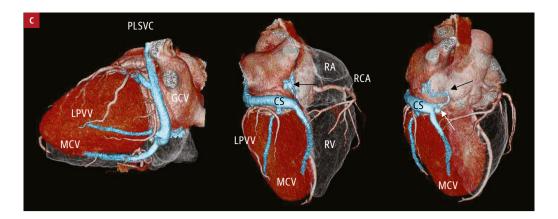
C – 3-dimensional volume-rendered reconstruction images of cardiac computed tomography showing atresia of the coronary sinus (CS) ostium with persistent left superior vena cava (PLSVC) (left, left posterior oblique view; middle, caudal view; right, right oblique caudal view). The right atrium (RA) and right ventricle (RV) are shown in outline for clarity. White arrow indicates an anomalous vein arising from the CS toward the left atrium. Black arrows indicate a side branch of the anomalous vein, which finally ended at the RA.
